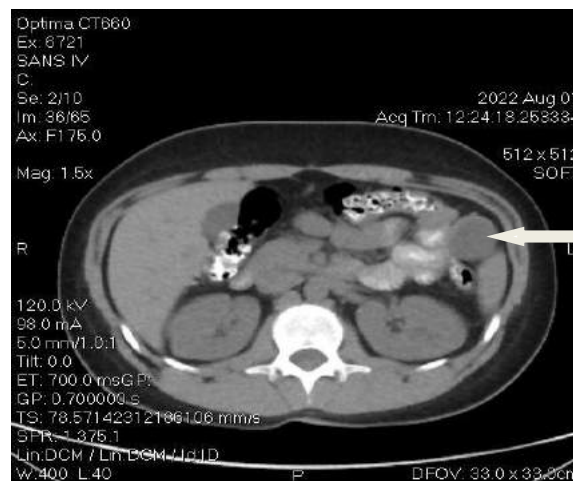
Abdominal CT, accessory spleen cyst
